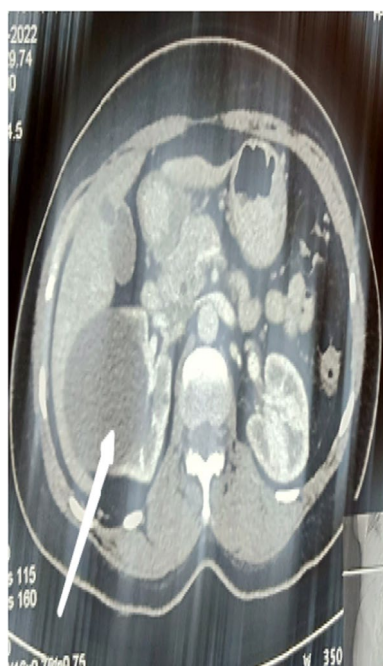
The computed tomography image of the right cystic kidney indicating an arrow showing septation with homogenous septal enhancement
